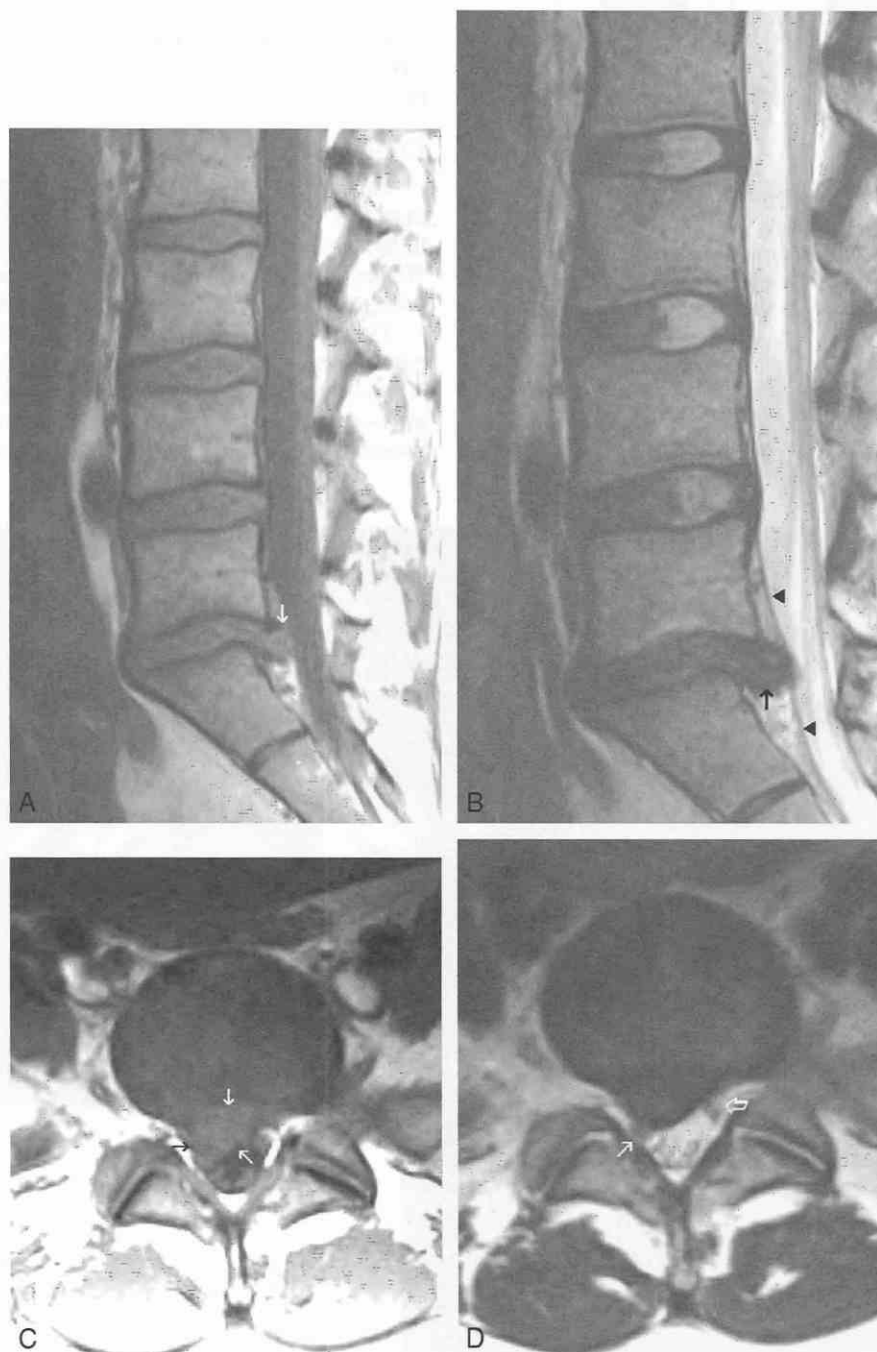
Various disk herniations as shown with MRI.
